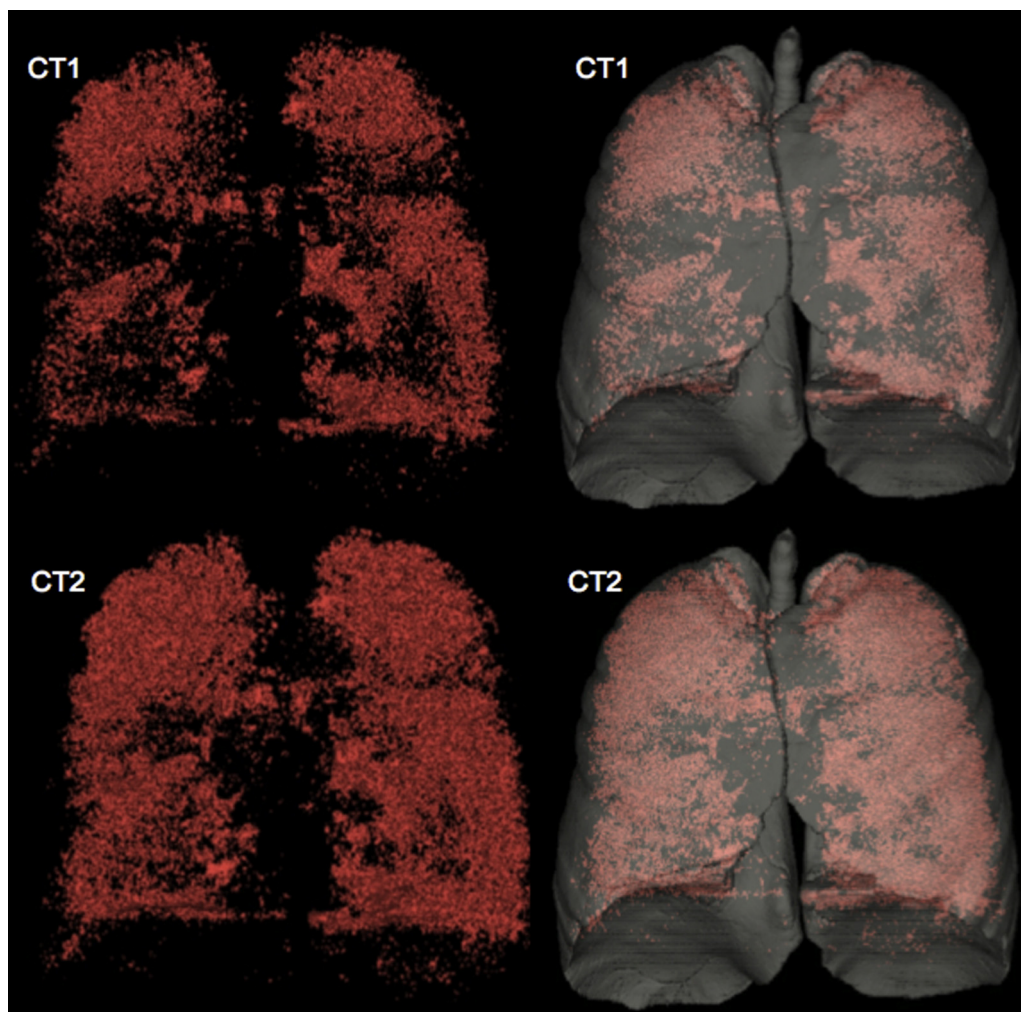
Frontal three-dimensional reformatted computed tomographic (CT) images of the same patient before (CT1) and after (CT2) the induction of dynamic hyperinflation.
